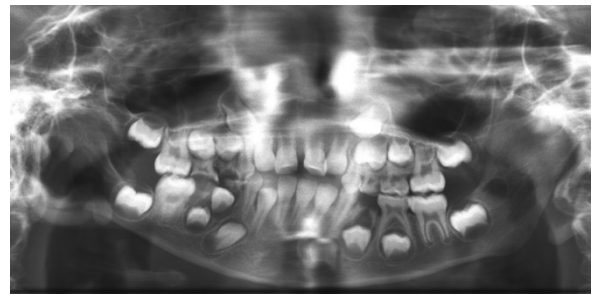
Panoramic radiograph showing aplasia of right condyle and coronoid process with decreased ramal height on right side.
